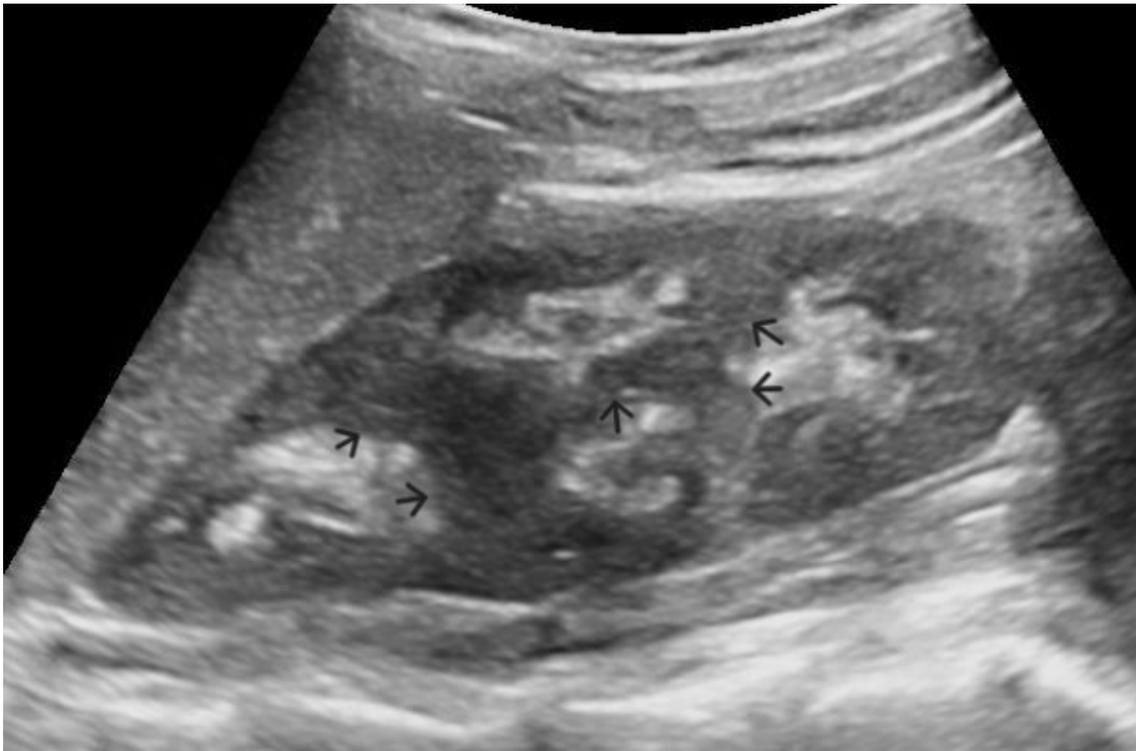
Ultrasound image of the left kidney (sagittal scan) shows multiple columnar masses (arrows) crossing the sinus and giving an appearance of a tetrafid renal sinus.
